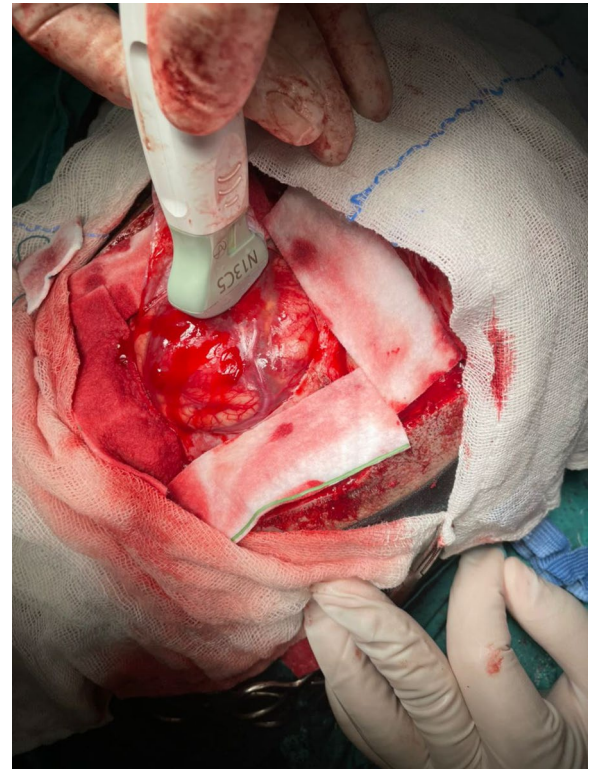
Place of ultrasound device in operating room
